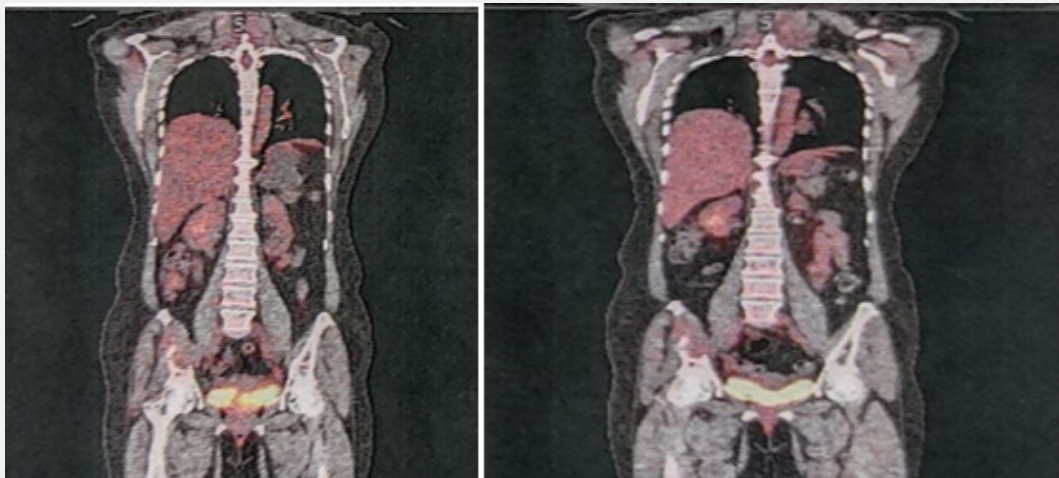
Coronal images of PET scan (a) Dec,23 and (b) March 24 showing stable disease with no new uptake. Patient then referred to radiation oncologist for opinion regarding localized radiation. She received IMRT 30Fr from 1st May,24 to 8th June,24 from Cache Flow up PET/CT scan done on 13th Sep,24 showed metabolically stable disease. The last PET/CT scan on 24th March 25 showed stable disease in bone Figure 5, clinically she was also asymptomatic so planned to keep on surveillance with 6 monthly PET scan.
